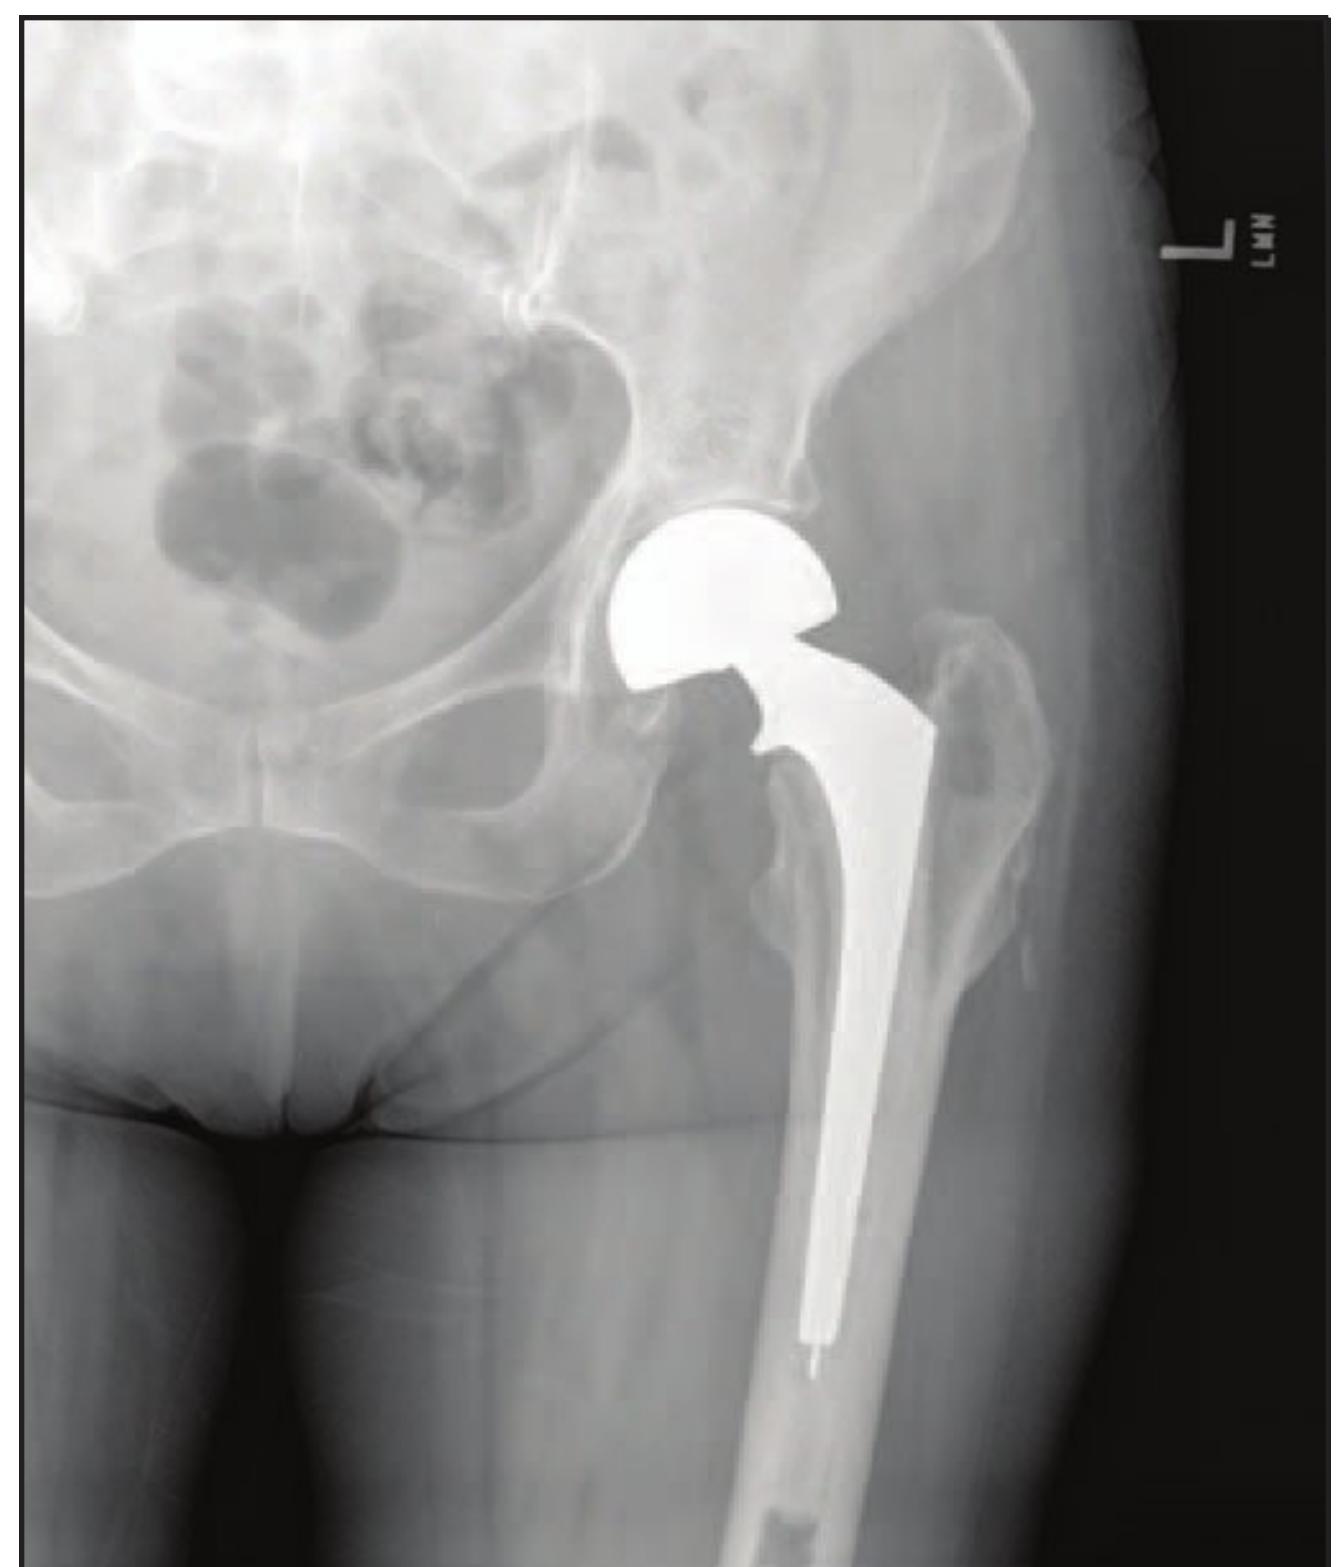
AP radiograph of a right hip hemiarthroplasty (bipolar) with an Omnifit EONstem. The stem has a collar.
